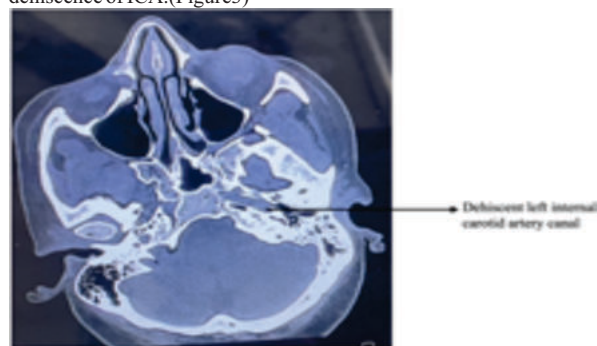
Axial HRCT view showing Dehiscent left internal carotid artery canal
